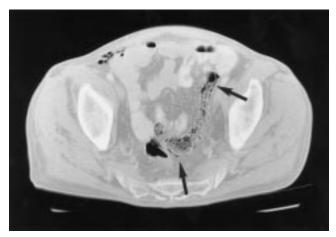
Contrast-enhanced CT of the abdomen performed on day +293 after transplantation at the level of the pelvis demonstrates extensive intramural gas collections in the wall of the sigmoid colon (arrows).
